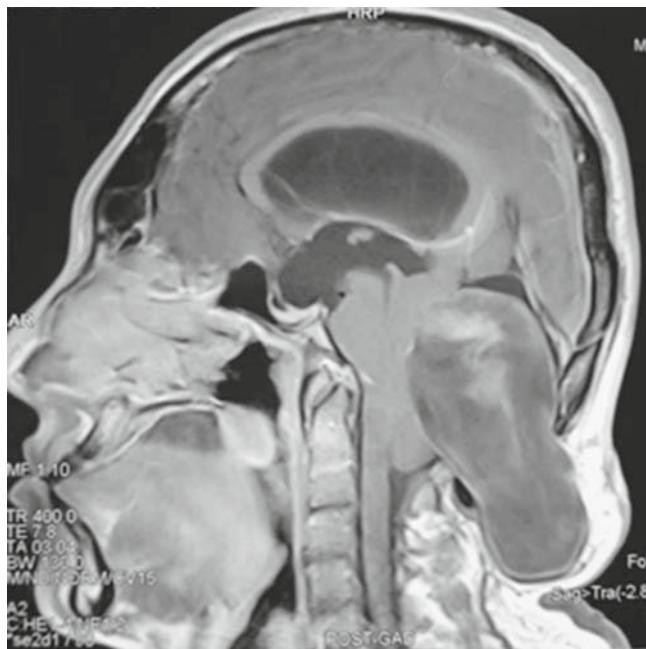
Sagittal T1-weighted magnetic resonance image, showing well-defined, hyperintense posterior fossa mass lesion, compressing the cerebellum and fourth ventricle and protruding extracranially through scalloped occiput
